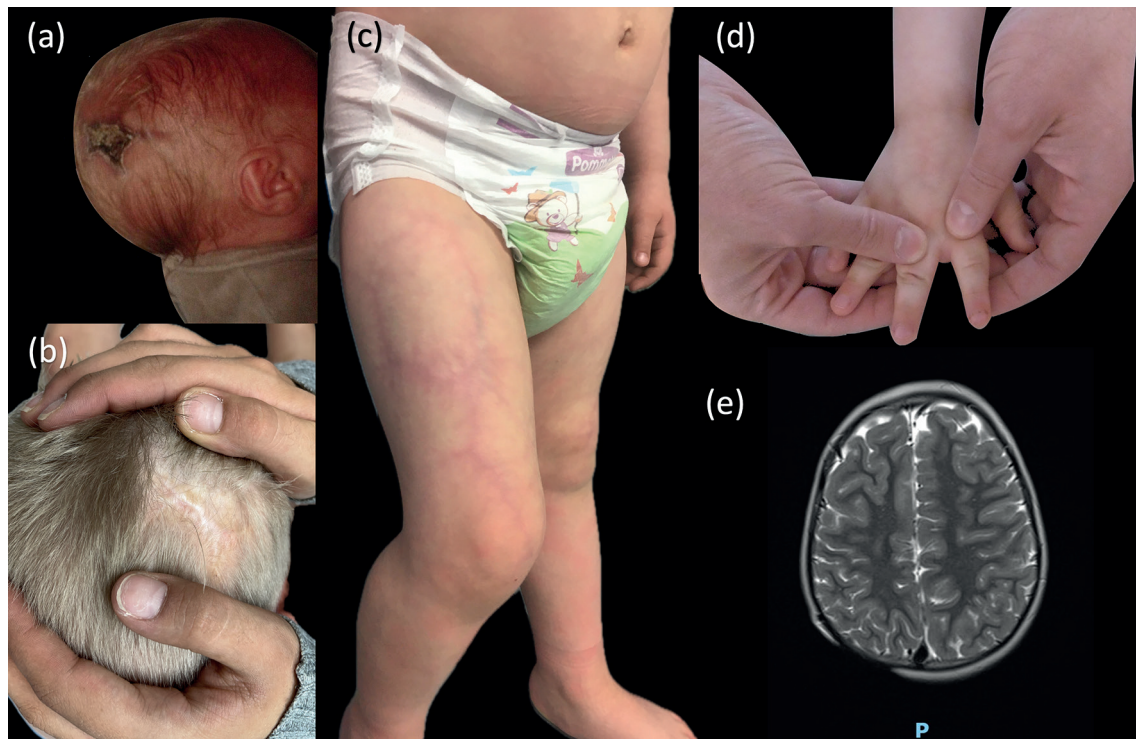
(a) Scalp defect at birth (aplasia cutis congenita). (b) Aplasia cutis congenita. (c) Cutis marmorata telangiectatica of the right leg. (d) Shortening of terminal phalanges of fingers (brachydactyly). (e) Brain MRI (axial section, T2-weighted image) showing a defect of the parietal bone.
